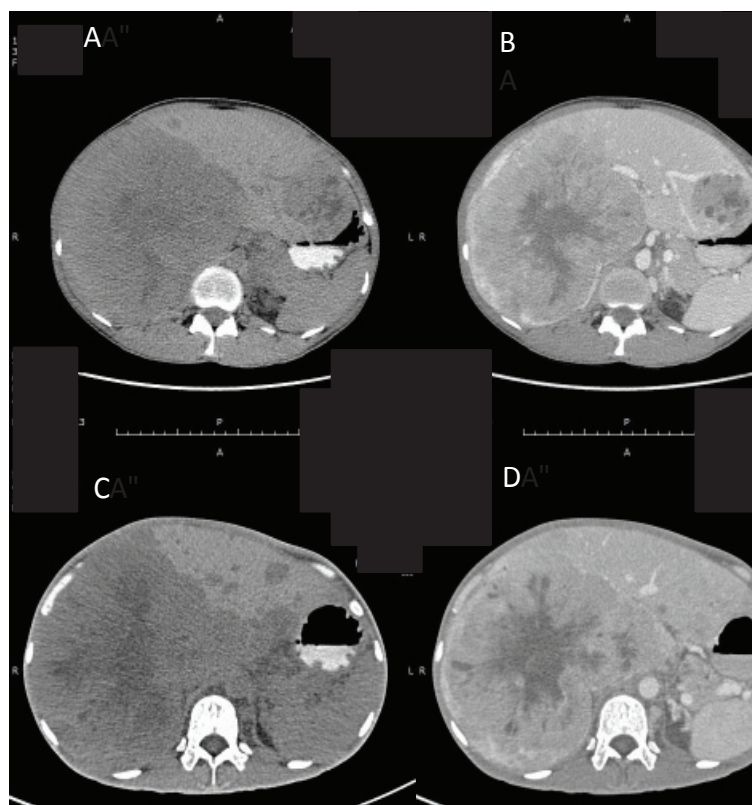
Stable disease in a 33-year-old female with liver metastases from gastric GIST; (a) Pre-treatment NECT, (b) Pre-treatment CECT, (c) Post-treatment NECT, (d) Post-treatment CECT. Follow up CT showing that liver mass size had increased slightly from 11.1x15.6 cm (33,51 HU) to 15.4x16.1 cm (39, 76 HU) on both NECT and CECT after nearly 3 months of treatment, due to soft tissue component with cystic change and area of hemorrhage, thus finding increased size and density of 3% and 18%, respectively, on NECT, and increased density of 49% on CECT.
